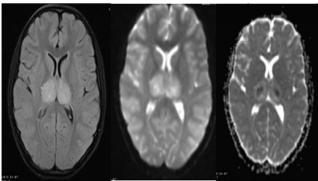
5b & 5c: Axial FLAIR a) showing symmetrical Bilateral Thalamic Hyperintensity. Diffusion weighted image b) and Apparent diffusion coefficient c) showing foci of diffusion restriction in Bilateral thalamic hyperintensity.
